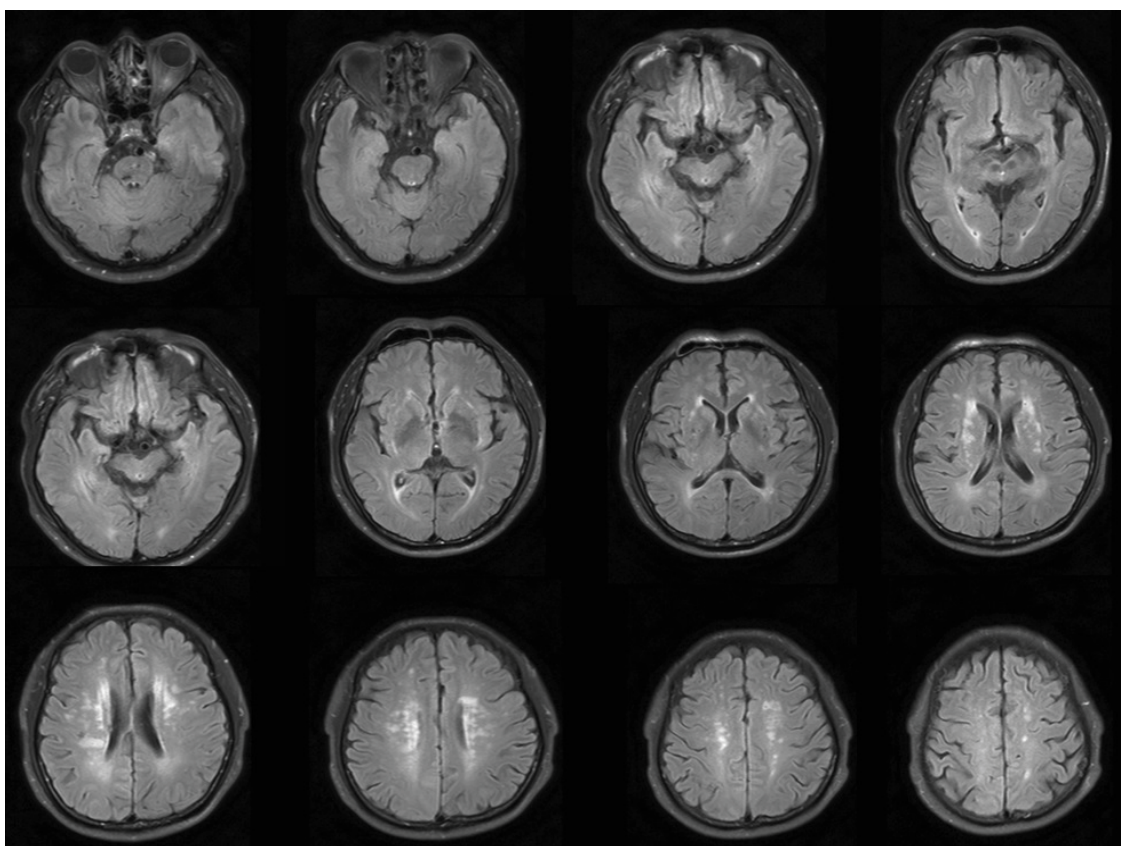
Magnetic resonance image showing acute infarctions within the right corona radiata and the left parietal lobe; previously documented multiple bilateral lacunar infarctions, and softening lesions in the pons and right basal ganglia with hemosiderosis and calcification.
